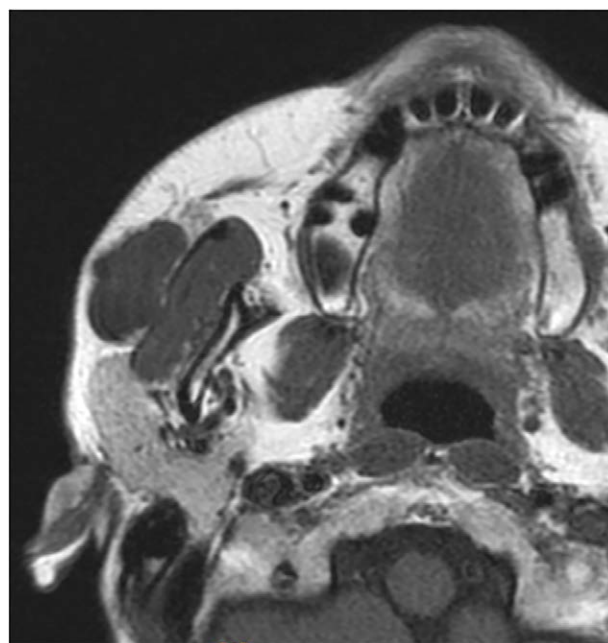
Axial MRI (T1-weighted image) showing a 14×27-mm mass with low signal intensity in the anterior masseter muscle. There was no obvious contact with the main parotid gland or Stensen duct.
